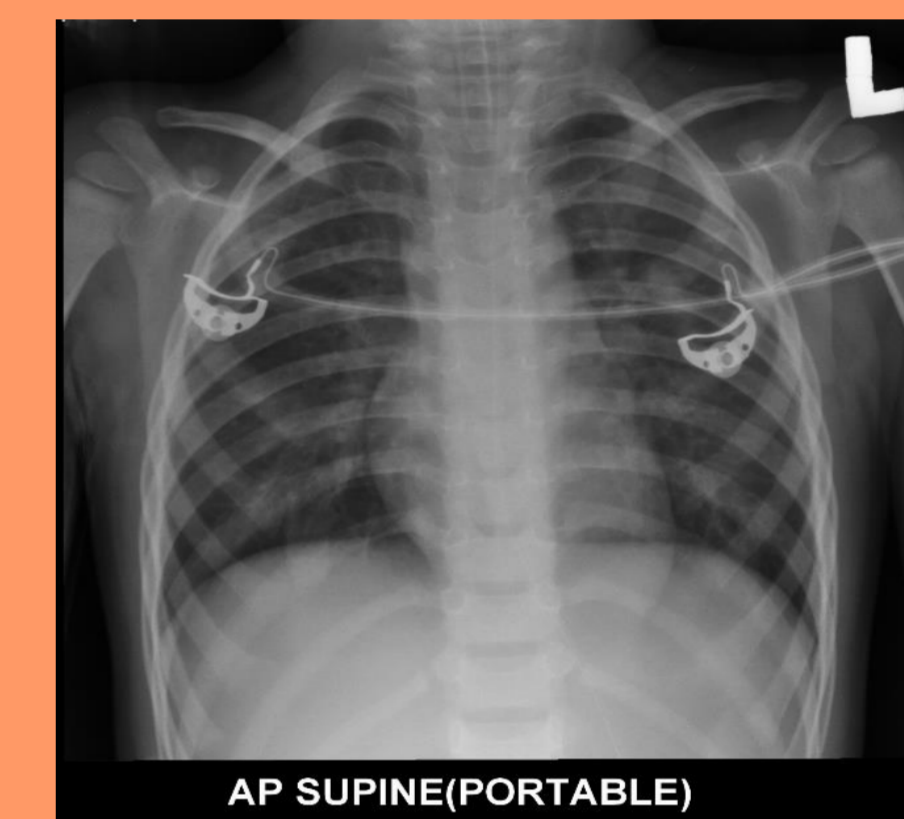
Chest radiograph with normal finding
